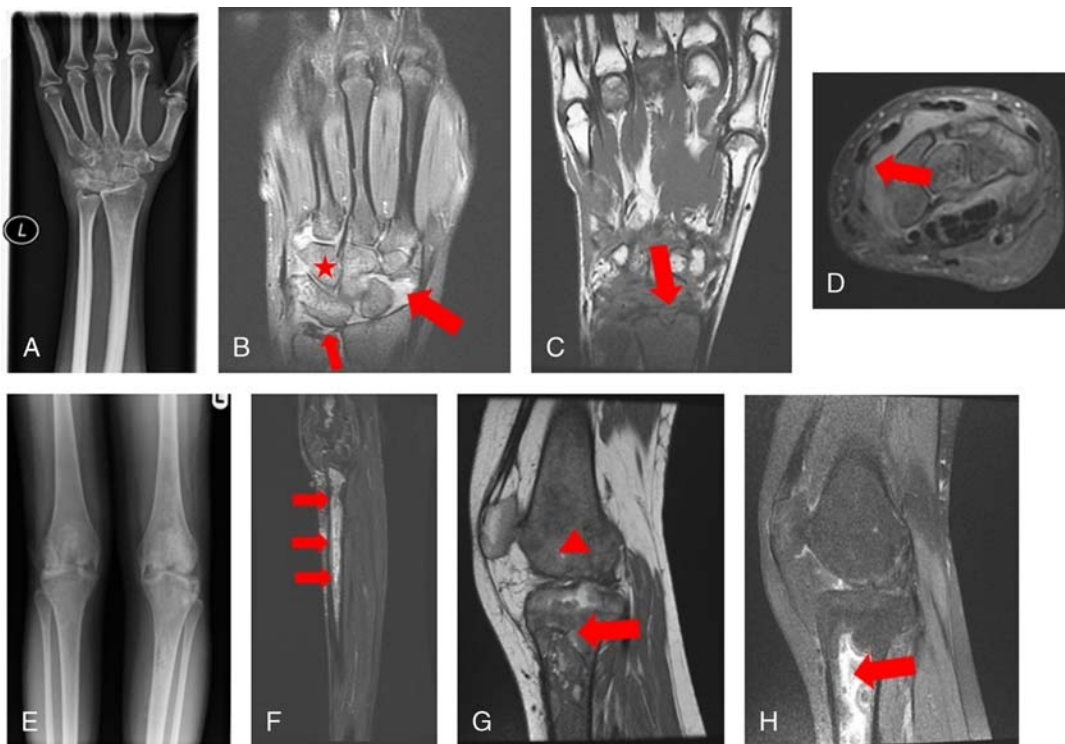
A–D, Hand. A, Radiograph of the left hand with loss of the joint space at the radiocarpal articulation. B, Magnetic resonance imaging coronal fluid-sensitive (short tau inversion recovery [STIR]) image of the left hand that demonstrates marked effusion and synovitis involving the radiocarpal joint (arrow); there is reactive bone marrow edema involving the carpal bones (star), and there is an incidental finding of a triangular fibrocartilage complex tear (small arrow). C, Magnetic resonance imaging T1 image of the left hand that demonstrates a focal erosion involving the distal radius (this was not visualized on the radiograph). D, Magnetic resonance imaging axial fluid-sensitive (STIR) image demonstrating marked effusion and synovitis within the wrist. E–H, Knees. E, Radiograph of both knees, weight-bearing views, demonstrates severe loss of joint space involving the tibiofemoral compartments; in addition, in the left proximal tibial shaft, there is sclerosis (arrow). F, Magnetic resonance imaging sagittal fluid image through the left tibia demonstrates extensive serpiginous signal change through the shaft in keeping with bone infarction (multiple arrows). G and H, Sagittal T1 (G) and Sagittal fluid-sensitive (STIR) images (H) demonstrating extensive infarction (arrows) involving the proximal tibia and background degenerative change at the knee joint, with loss of normal marrow signal of the distal femur (triangle) (G).
